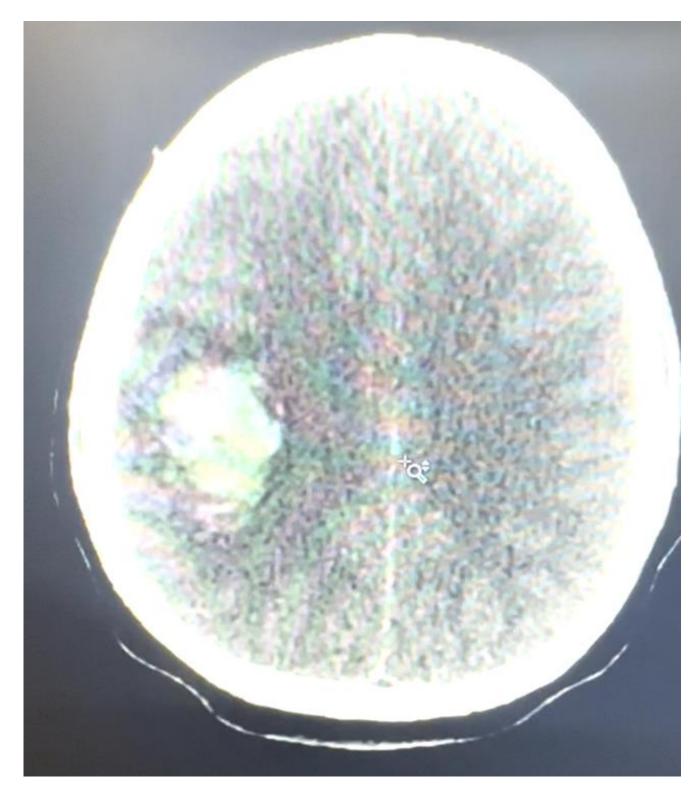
Initial CT Head- anterior-posterior right frontal lobe hematoma
